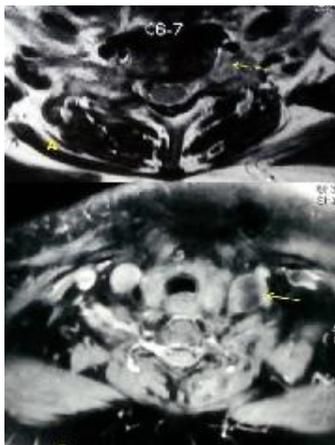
Magnetic resonance imaging picture showing the metastatic lesion at the C6/7 level. (A) T2 weighted image (B) T1 weighted image
